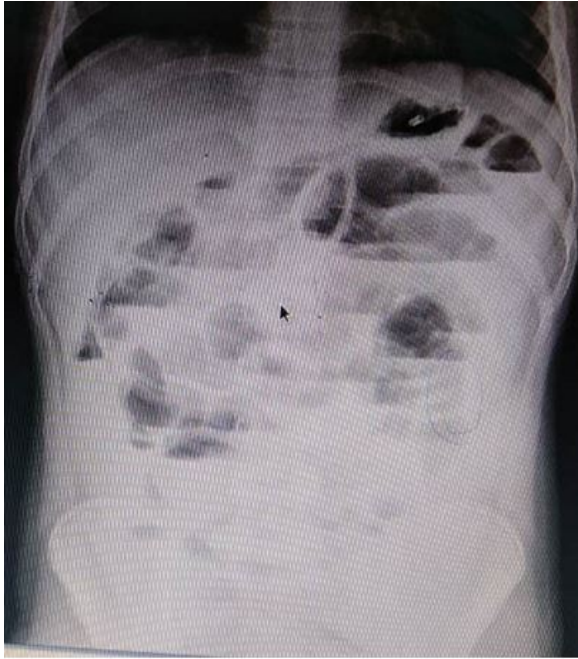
Multiple Air Fluid Levels seen on Xray Abdomen Erect in a patient with Small Bowel obstruction
